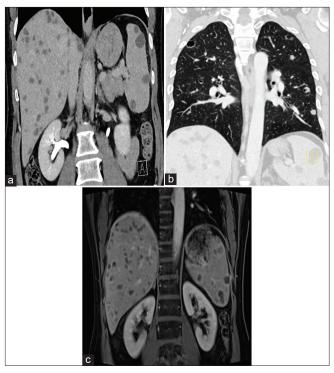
(a) Computed tomography abdomen, (b) chest, and (c) magnetic resonance imaging abdomen showing diffuse non-specific variable sized hepatic/splenic cystic lesions with similar bilateral innumerable pulmonary nodules/cysts, some of them showed definite cavitations.
